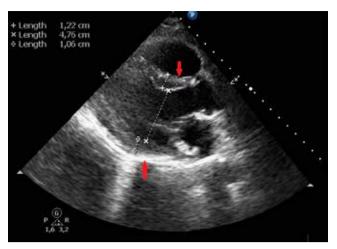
Echocardiography performed at discharge: Parasternal long axis view in diastole. Normal thickness of the septum and posterior wall
